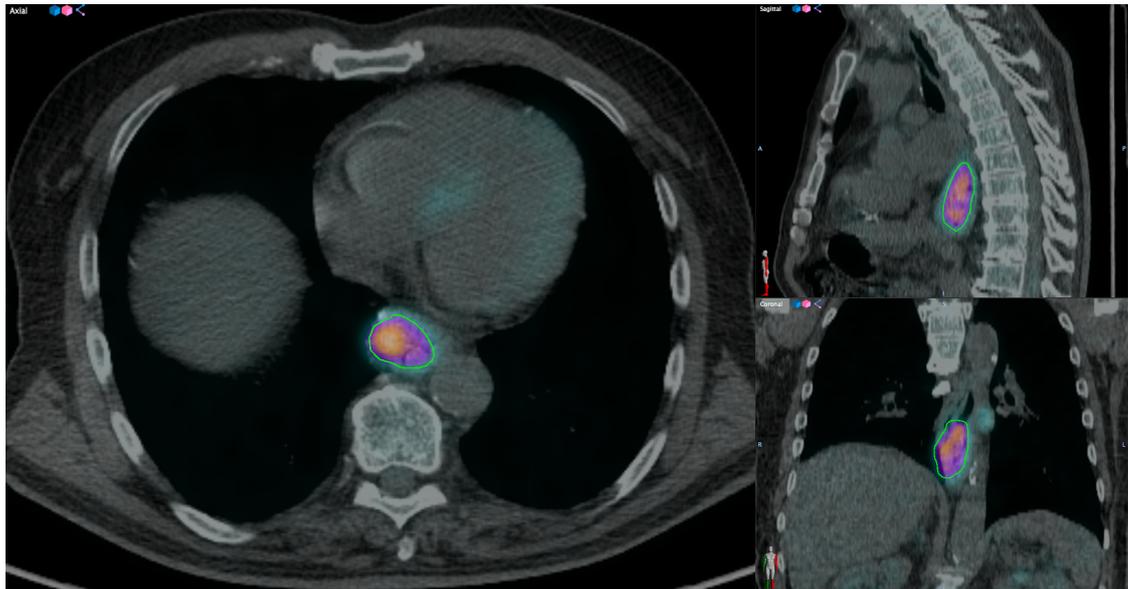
An example of axial, sagittal and coronal fused PET/CT images showing a FDG-avid mid-oesophageal tumour segmented with ATLAAS (green contour). PET images are co-registered with the corresponding CT images and the ATLAAS contour of the FDG-avid primary tumour is displayed.
